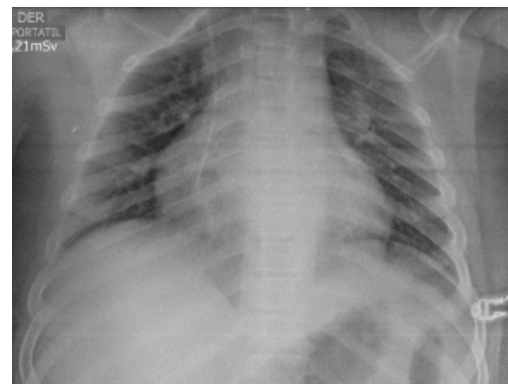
Chest x-ray: diffuse parenchymal/alveolar opacities. Source: Document obtained during the study.
